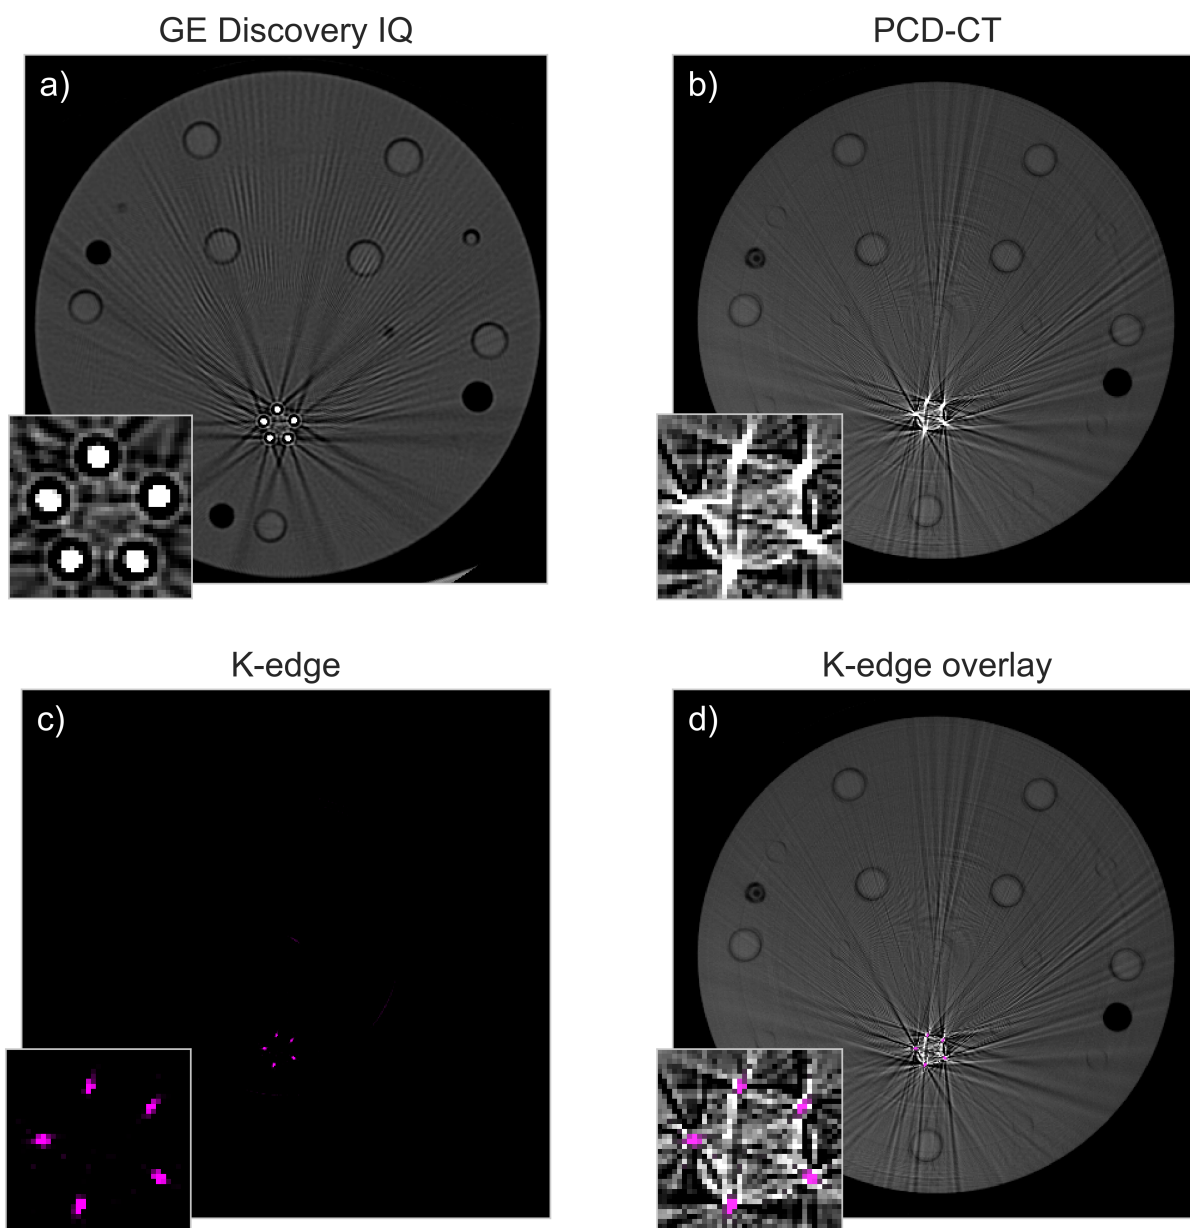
K-edge subtraction of radiopaque markers of the Cordis S.M.A.R.T. Control stent. CT image acquired with the a) GE Discovery IQ and b) PCD-CT. c) Ta K-edge decomposition image. d) PCD-CT image with the Ta K-edge image overlaid on top of it. $W/L = [2100/450]$.
